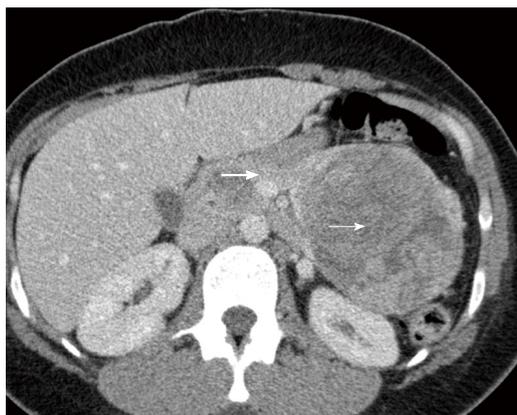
Computed tomography scan of the abdomen showing a large tumor in the pancreatic tail (fine arrow) and a small tumor in the pancreatic head (thick arrow).
